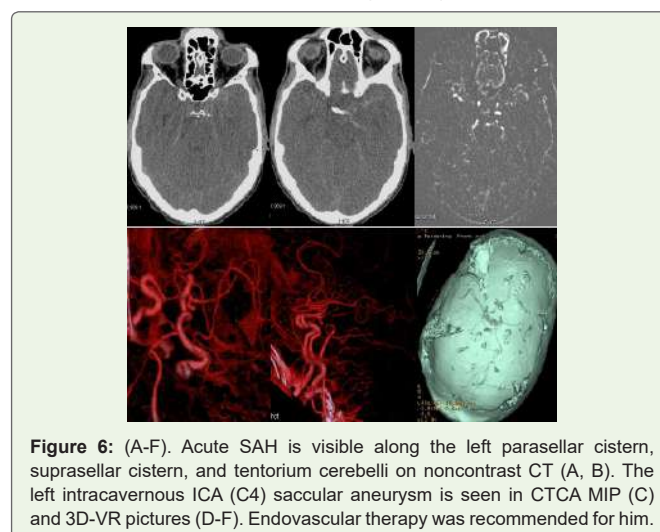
(A-F). Acute SAH is visible along the left parasellar cistern, suprasellar cistern, and tentorium cerebelli on noncontrast CT (A, B). The left intracavernous ICA (C4) saccular aneurysm is seen in CTCA MIP (C) and 3D-VR pictures (D-F). Endovascular therapy was recommended for him.
